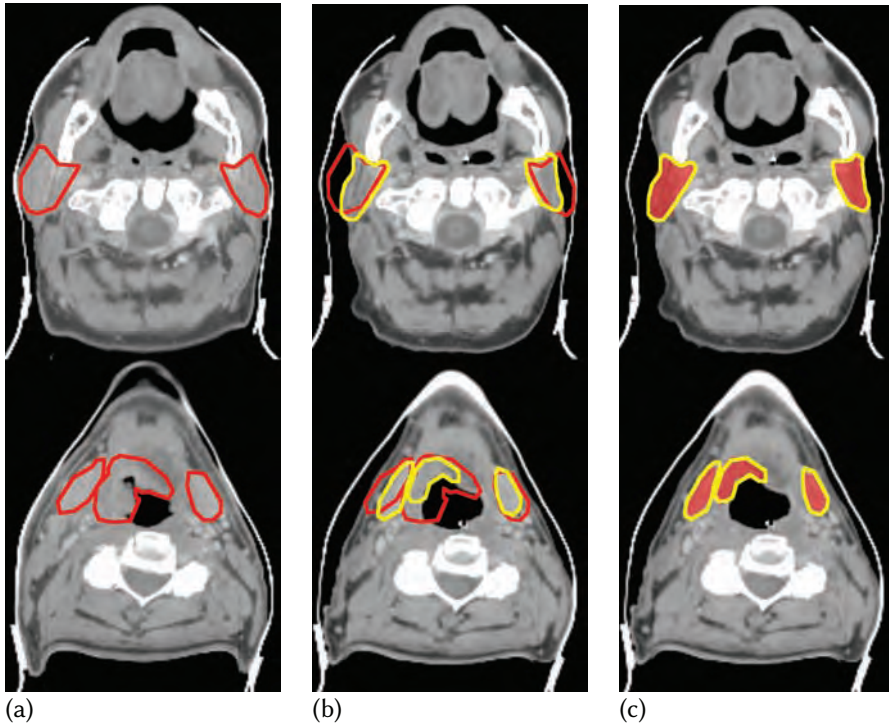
Example of observed shape and position changes for a H&N patient (bilateral neck treatment). Shown in the upper slices are the parotid glands and in the lower slices the submandibular glands and primary tumor. (a): planning CT and delineated structures in red. (b): Post-EBRT CT with planning (red contours), and Post-EBRT (yellow contours) delineations. (c): Post-EBRT CT with delineated structures (yellow contours), and transformed planning structures (shadow).
